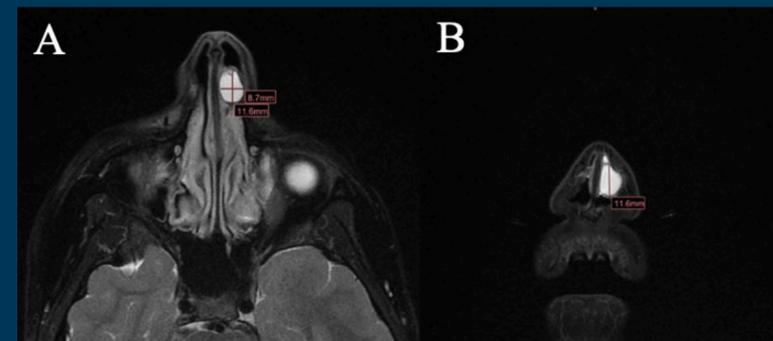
T2-weighted Magnetic Resonance Imaging (MRI) with lesion seen as hyperintense in the left nasal vault. A) Axial Cut B) Coronal Cut
